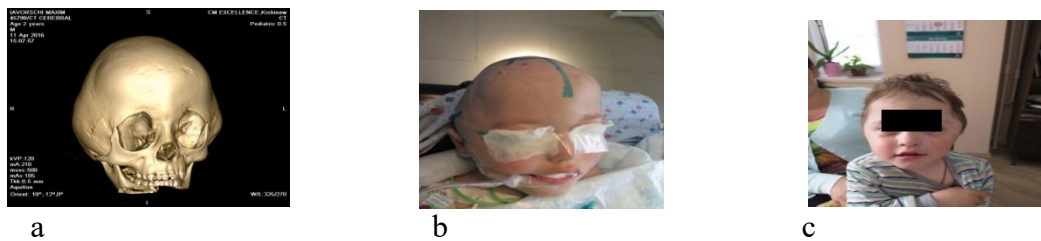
Multiple craniosynostosis: a) CT image; b and c) the image of the patient
